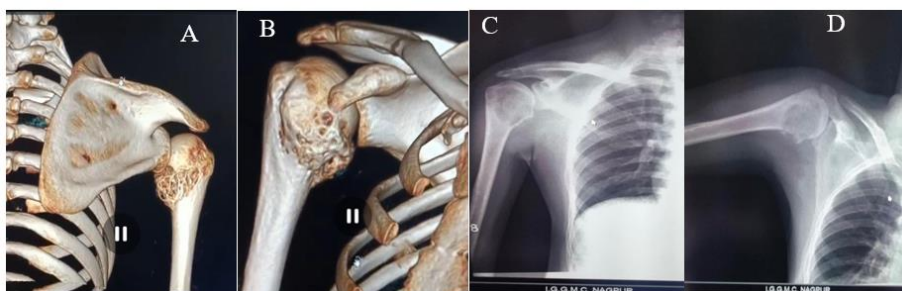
(A) & (B) Preoperative 3D CT images. (C) & (D) showing well defined lytic lesion of proximal humerus
